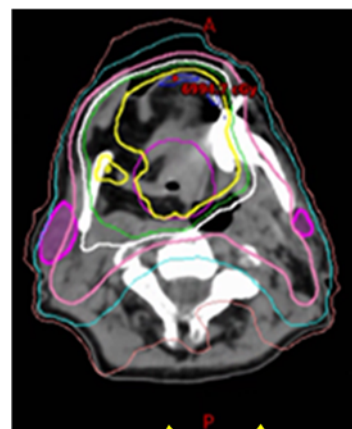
Treatment plan CT slice superior to the slice in 13a, showing relative sparing of left parotid (parotids are pink volumes adjacent to mandible). Image courtesy of the University of Massachusetts Medical School, Department of Radiation Oncology.
